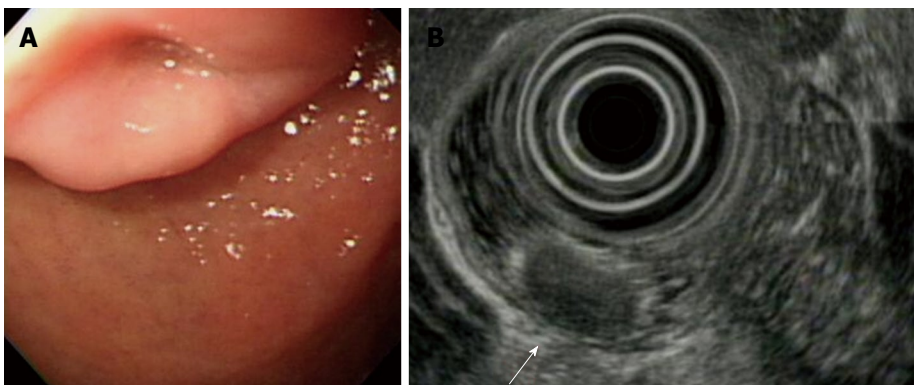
Endoscopic findings of carcinoid tumors. A: Endoscopy revealed an elevated lesion with a central dimpling in the bulb of the duodenum; B: Endoscopic ultrasound finding showed a round-shaped homogenous hypoechoic mass in the mucosal and muscularis mucosal layer (arrow).
